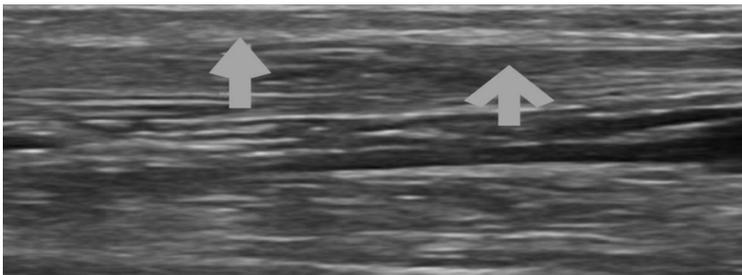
B-ultrasound images of patients with thrombosis. An internal fistula thrombosis can cause vascular occlusion, which will not automatically restore patency under normal circumstances. Table 1 suggests that the blood flow parameters of patients with complications will be reduced to varying degrees. Figure 6 shows that the thrombus fills the vascular cavity, is relatively firm, occluding the surrounding space, and the activity of the squeezed vessel thrombus is diminished. Thus the stenosis leads to thrombosis.
